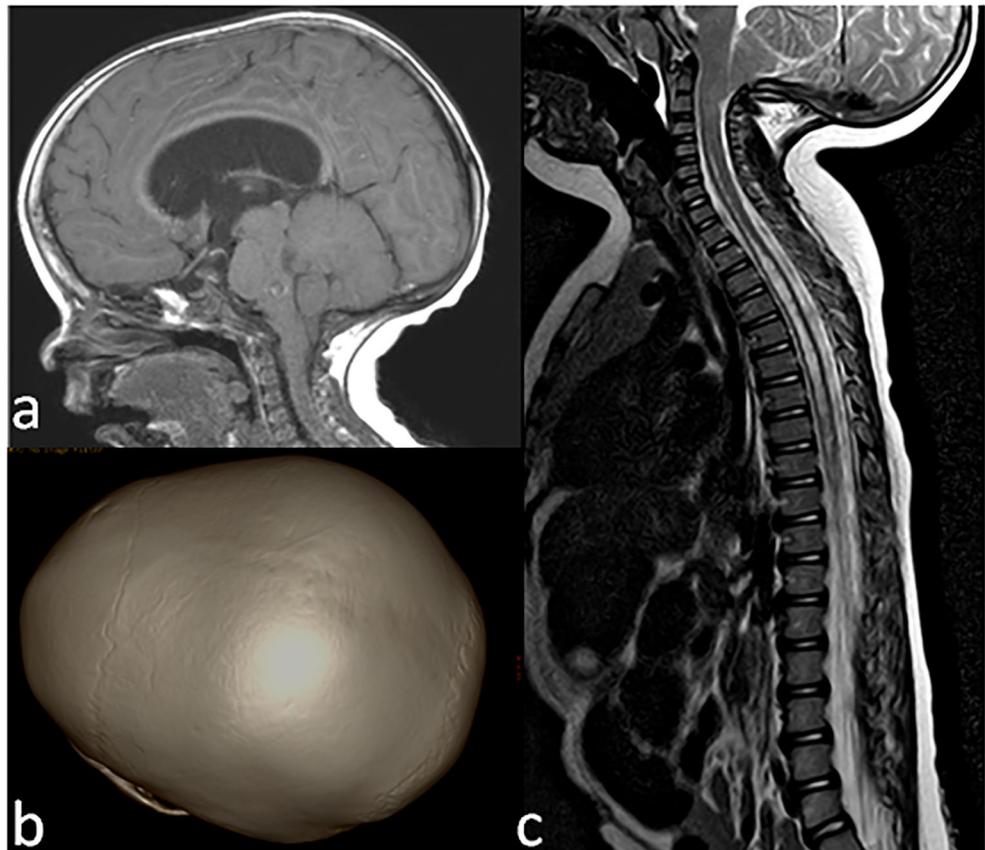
Noonan syndrome with craniosynostosis and CMI with syrinx. Due to the onset of typical Chiari headache, this 14-year-old girl performed brain MRI, showing CMI and cervico-dorsal syringomyelia (a T2-weighted sagittal scan). The scaphocephalic head morphology
